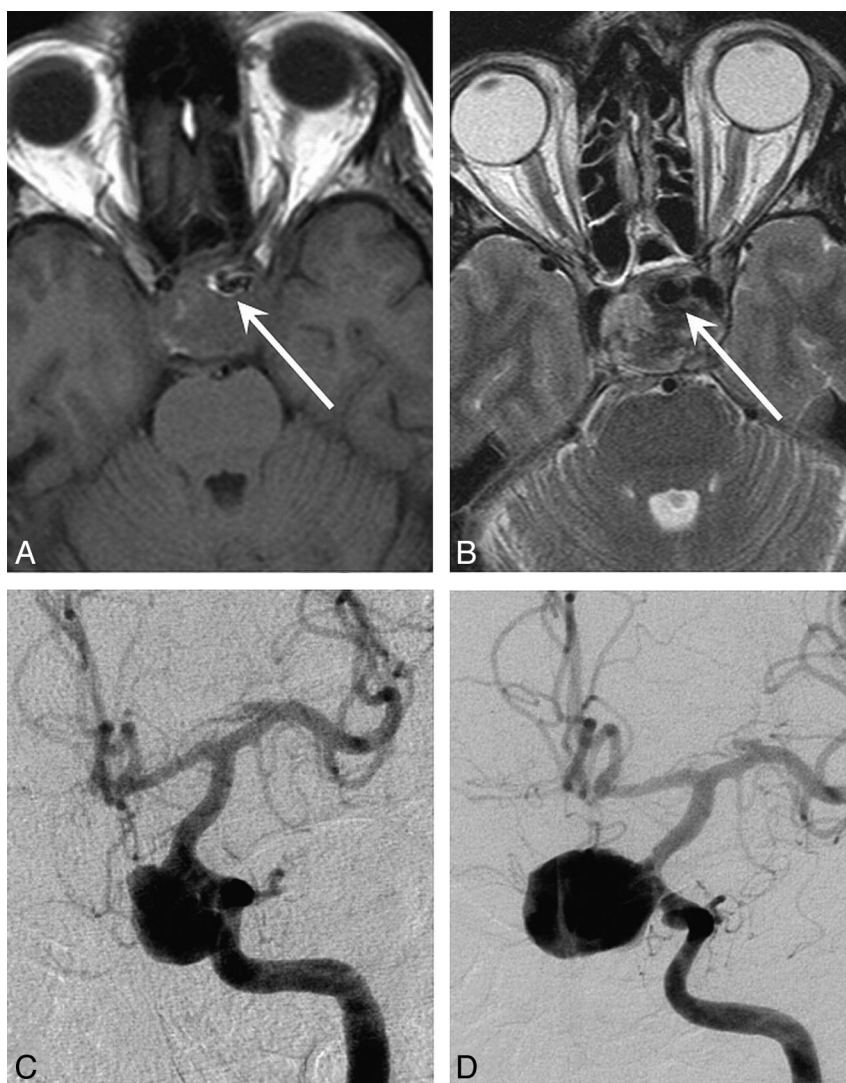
A 43-year-old man with acute left ophthalmoplegia. *A* and *B*, T1- and T2-weighted MR images demonstrate a largely thrombosed carotid hypophyseal aneurysm with a small lumen (arrows). *C*, Angiogram 2 days after MR imaging shows the aneurysmal lumen that appears larger by resolution of thrombus. *D*, Angiogram 16 days after MR imaging demonstrates complete resolution of intraluminal thrombus.
